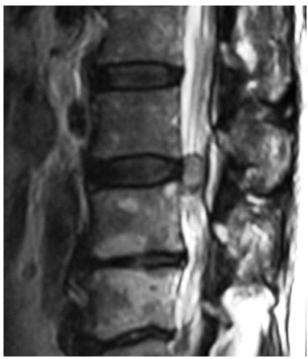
Case 2, MRI study of paraganglioma, T2 weighted image, sagittal view
